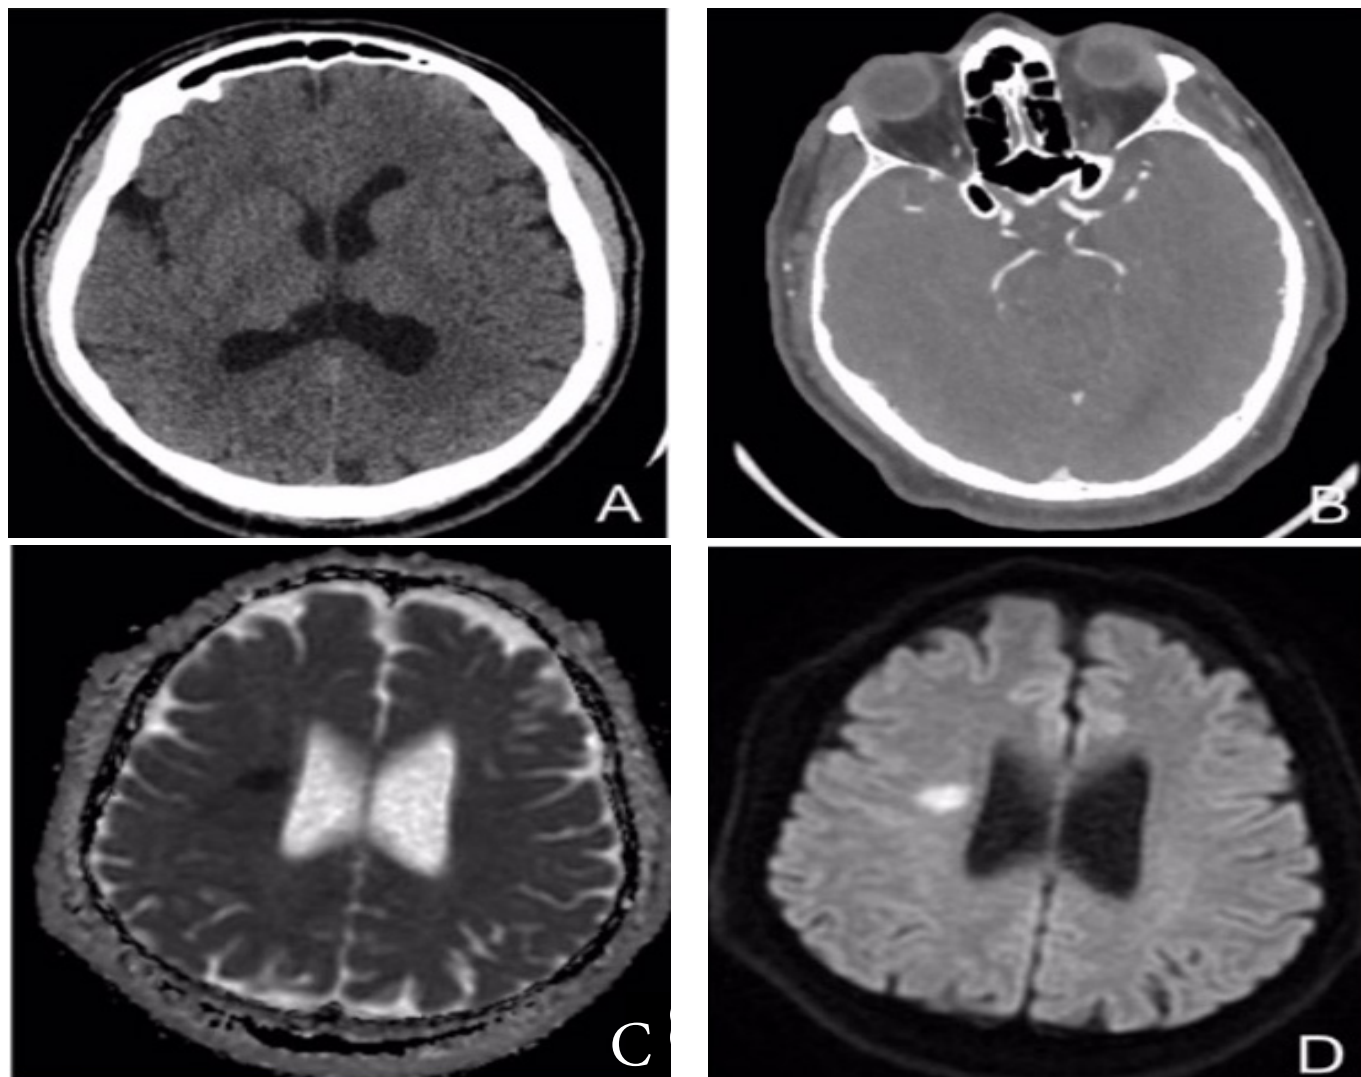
A) The brain computed tomography scan did not reveal any signs of intracranial bleeding. B) There was no major vessel occlusion in the cerebral angiography. C) Acute diffusion restriction detected in the centrum ovale on apparent diffusion coefficient (ADC) magnetic resonance imaging sequence. D) The hyperintensity observed in the diffusion-weighted imaging (DWI) scan is consistent with acute ischemic stroke
